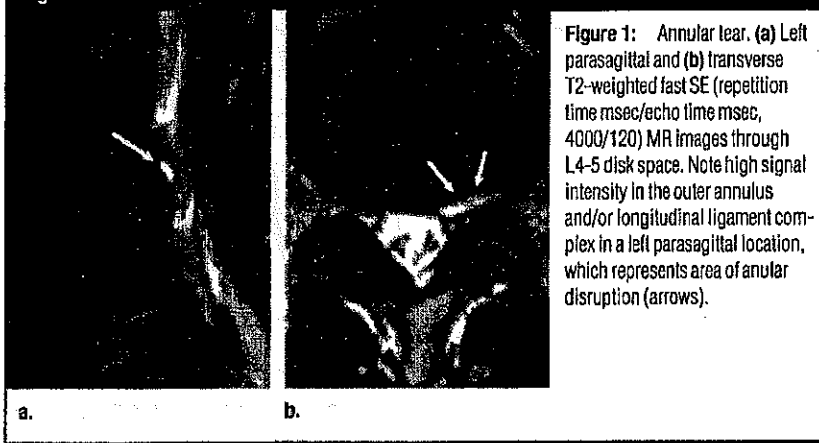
Annular tear. (a) Left parasagittal and (b) transverse T2-weighted fast SE (repetition time msec/echo time msec, 4000/120) MR images through L4-5 disk space. Note high signal intensity in the outer annulus and/or longitudinal ligament complex in a left parasagittal location, which represents area of annular disruption (arrows).
